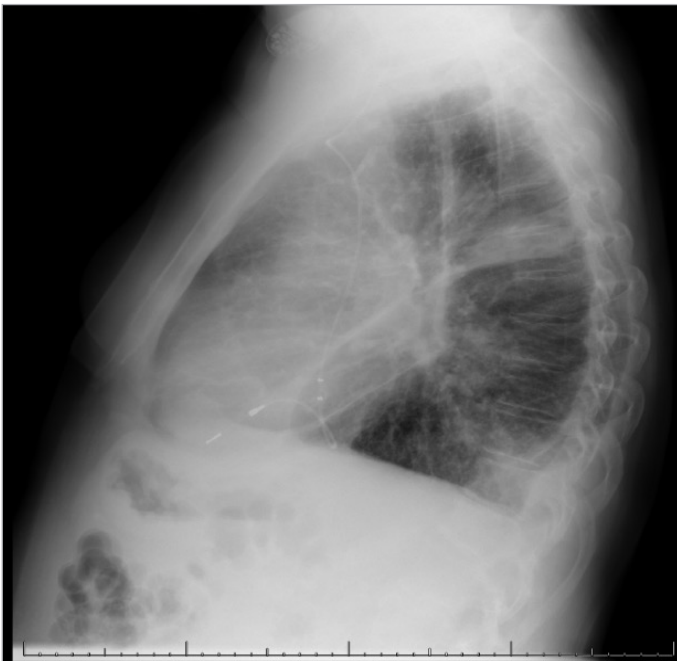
Chest x-ray corresponding to admission. Lateral view. It showed data of water overload and bilateral opacities probably related to pneumonic foci.
